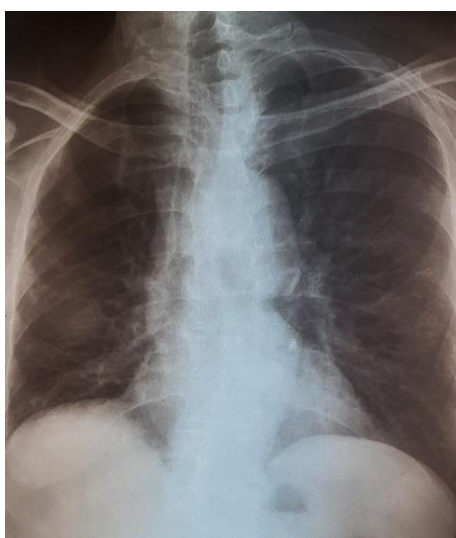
Frontal chest radiograph depicting a low-density pulmonary opacity in the right inferior hemithorax
